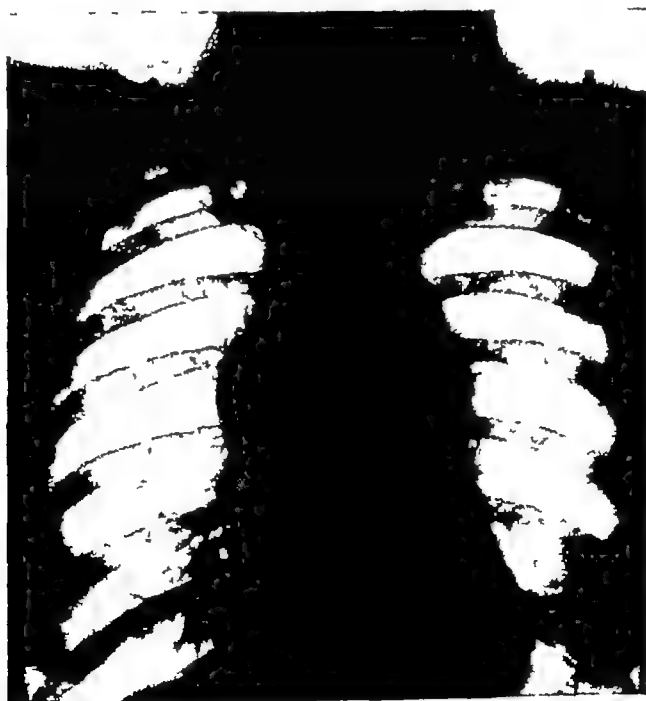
13 (a) —Radiograph of the chest showing a large mass in the mediastinum (see text)
